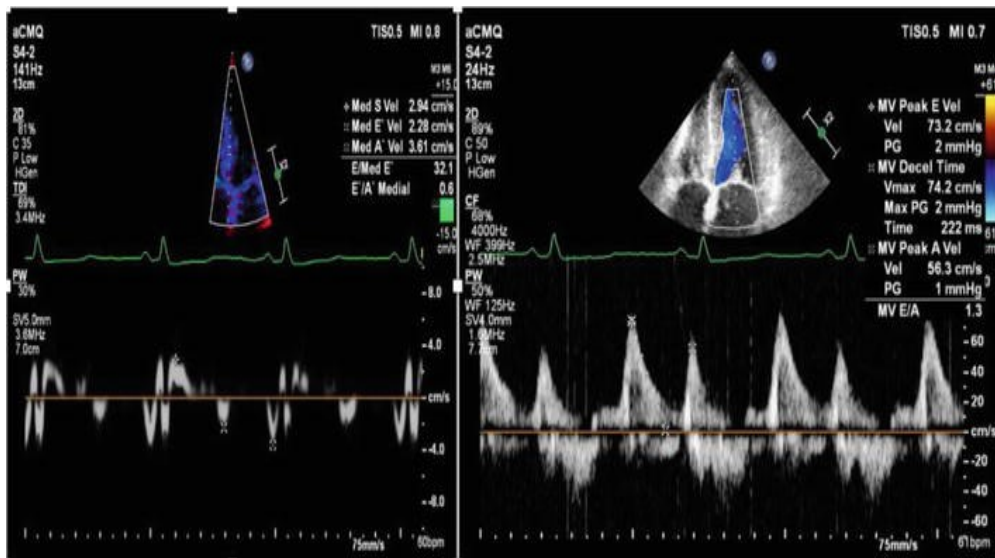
echocardiogram with tissue Doppler sample at base of the interventricular septum and pulsed-wave Doppler at mitral valve inflow in a patient with AL type cardiac amyloidosis revealing impaired relaxation, septal e' of the LV decreased and a pseudonormal pattern.
